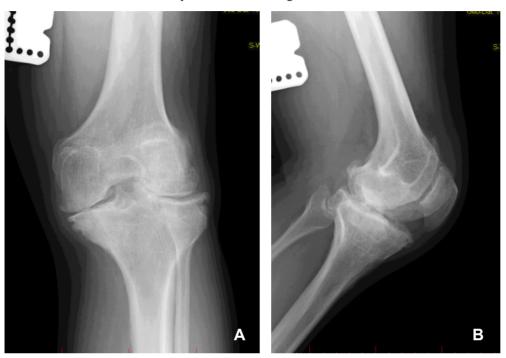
Haemophilic arthropathy of the knee joint, X-ray before surgery (a and b)
